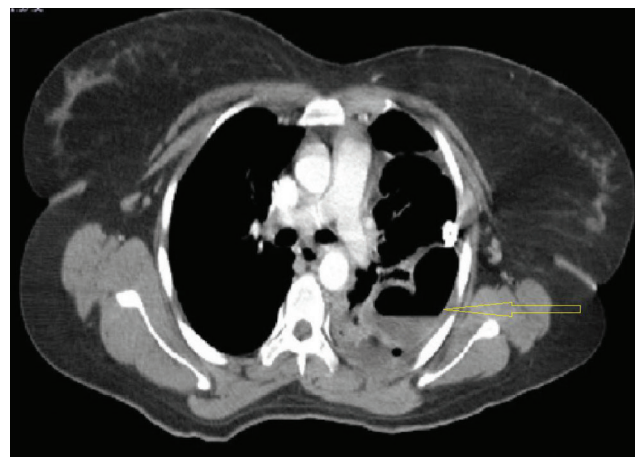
CT thorax showed left lung volume loss with hydropneumothorax with fibrosis, collapse and consolidatory changes
